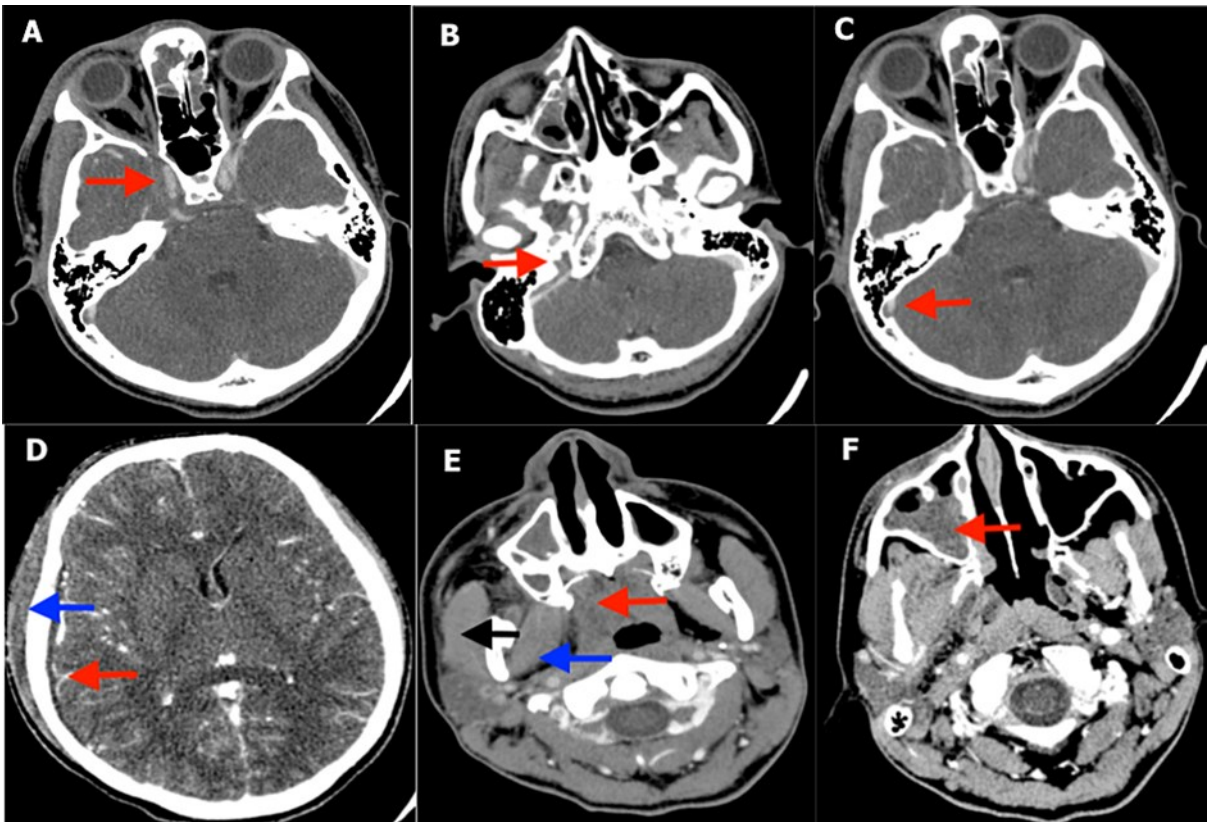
Axial brain Contrast Enhanced Computed Tomography:
